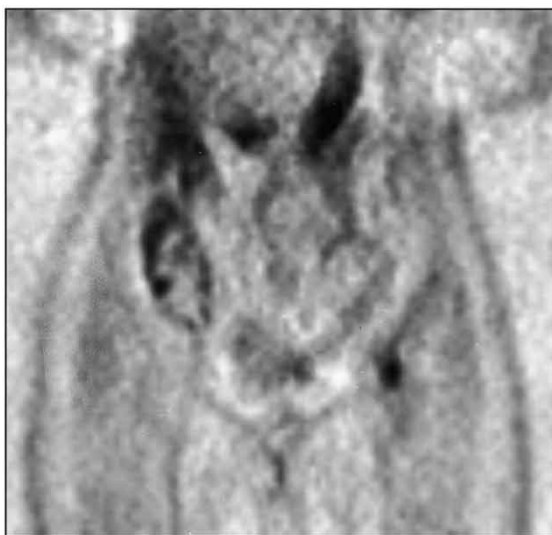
Coronal and transaxial FDG-PET study in patient No. 1 who previously underwent resection of a cutaneous melanoma of the leg. PET detected a lesion in the groin.
